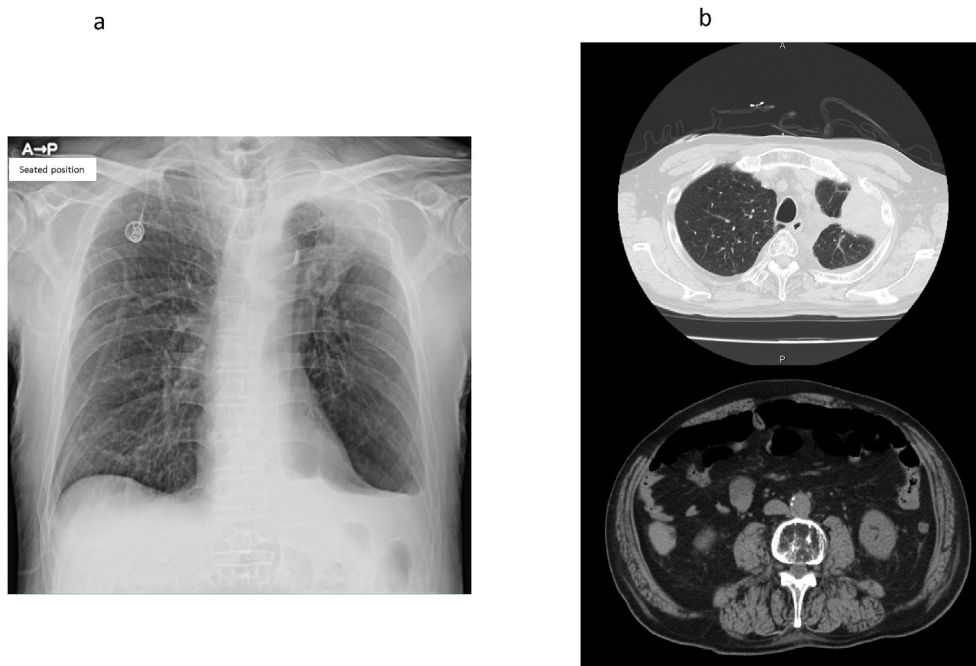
a. Chest roentgenogram. X-ray findings at admission included a tumor mass shadow in the upper lung field, left costophrenic (CP) angle blunting, and a central venous access port device planted in the left subclavian vein. b. Plain chest-abdominal computed tomography (CT). CT findings included a 50-mm tumor mass shadow in the left superior lobe, left pleural effusion, and absence of gut distention or niveau formation.
